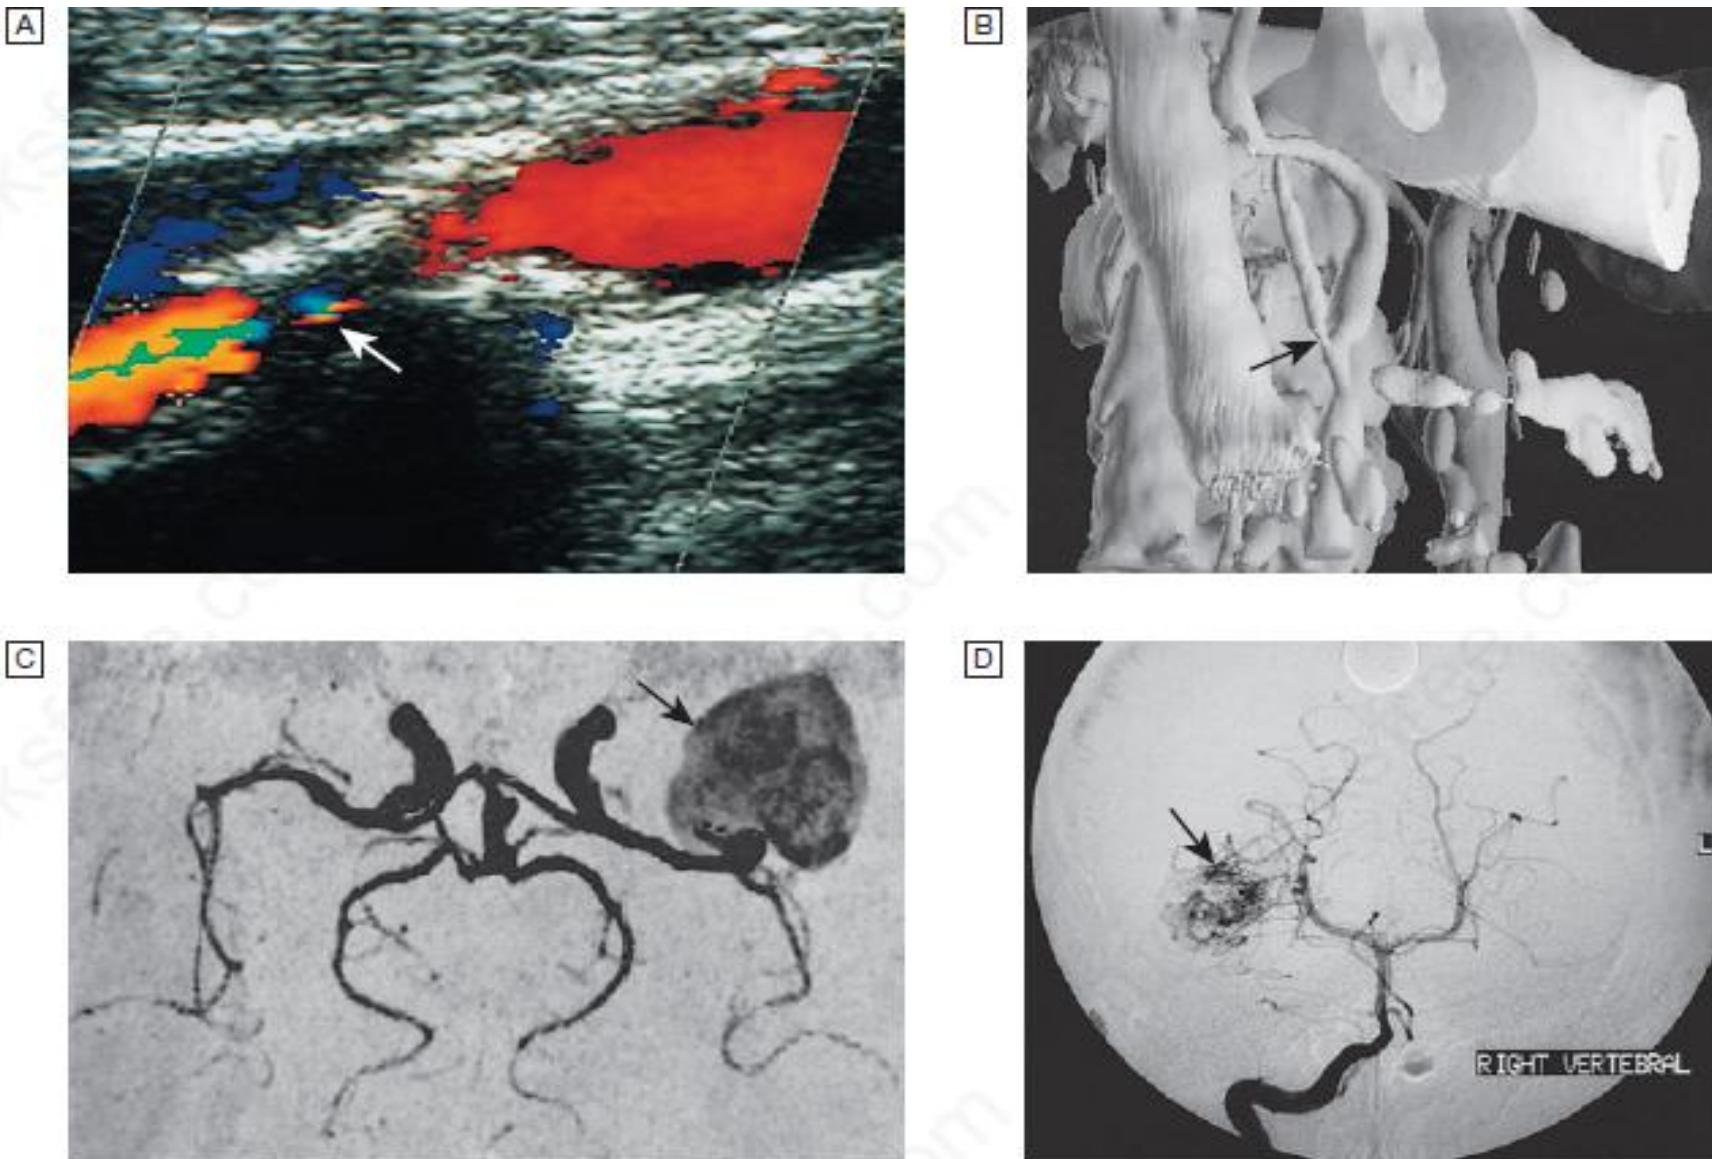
Different techniques for imaging blood vessels. A Doppler scan showing 80% stenosis of the internal carotid artery (arrow). B Three-dimensional reconstruction of CT angiogram showing stenosis at the carotid bifurcation (arrow). C MR angiogram showing giant aneurysm at the middle cerebral artery bifurcation (arrow). D Intra-arterial angiography showing arteriovenous malformation (arrow). *A–D, Courtesy of Dr D. Collie.*
